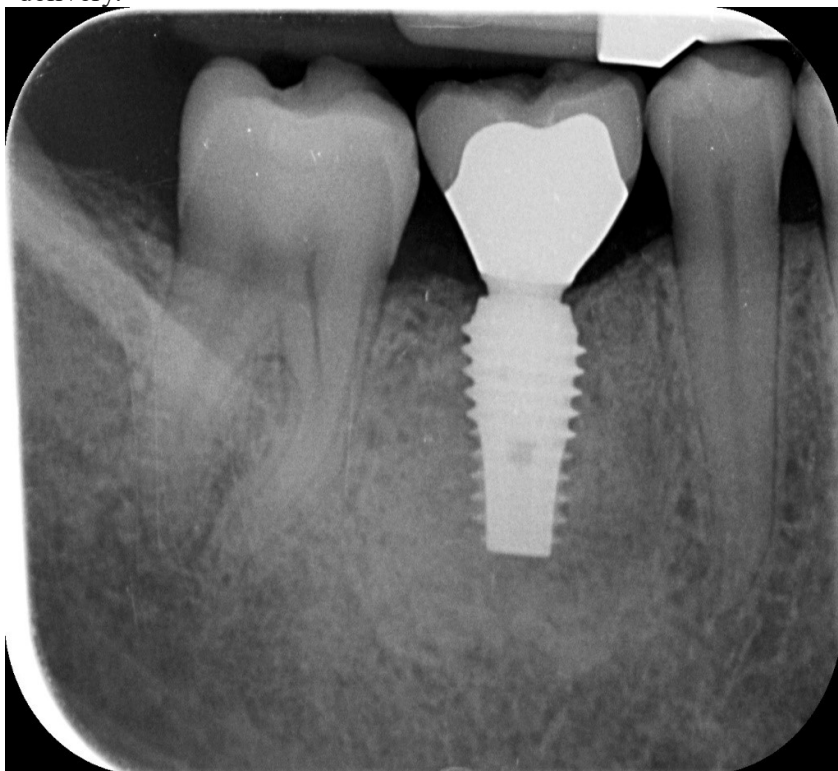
Case 3: periapical radiograph at the 5-year follow-up.
